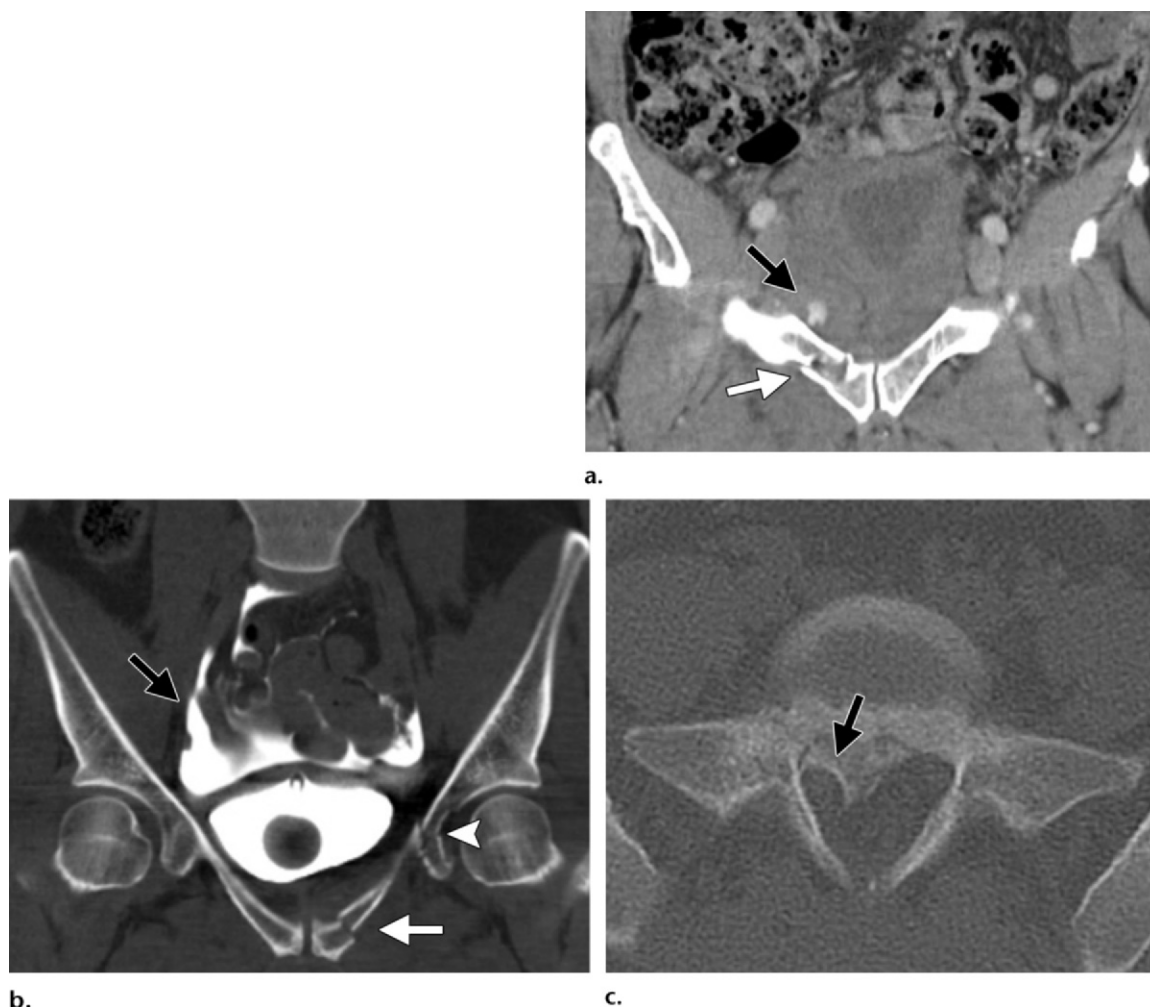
Complications of lateral compression injuries in three patients. (a) Coronal CT image obtained at the level of the pelvis in a 33-year-old woman shows active extravasation of contrast material from an internal iliac artery branch (black arrow), a result of a direct bone injury. Note the overlapping pubic ramus fracture (white arrow), a finding in keeping with a lateral compression injury. (b) Coronal CT cystogram obtained in a 22-year-old man shows leakage of contrast material into the peritoneal cavity (black arrow), a finding consistent with intraperitoneal rupture of the urinary bladder, a result of increased pressure from a lateral compression. Note the fractures of the superior pubic ramus (white arrow) and medial acetabular wall (arrowhead), signs of a severe injury. (c) Axial CT image obtained at the level of the sacrum in a 40-year-old woman with a lateral compression type 1 injury shows a sacral osseous fragment compressing the sacral nerve roots (arrow).
